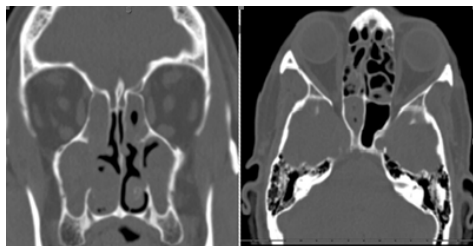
Figure (a) 37 years old male CT coronal view showing patient with complete opacification of PNS. Figure (b) 47 years old female CT axial view showing features of invasive fungal sinusitis in right frontal and posterior ethmoidal air cells.
